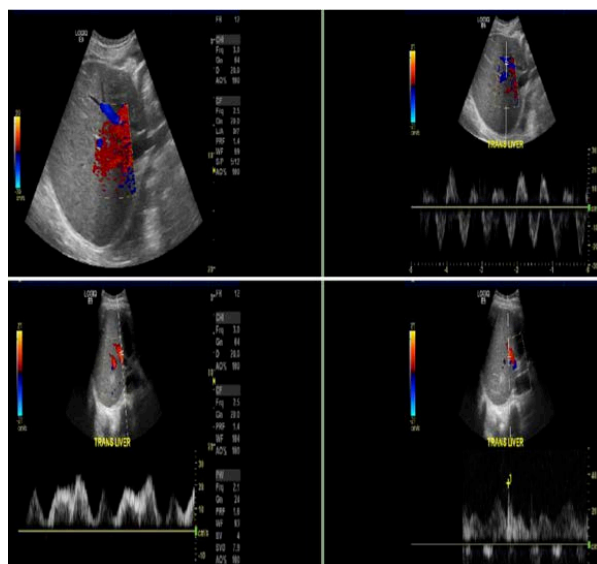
Ultrasonography liver: Mild diffuse coarse hepatic echotexture. 2.2 cm nonvascular echogenic focus posterior right hepatic lobe, potentially hemangioma likely reflecting roughly 2 cm partially low-density lesion with peripheral nodular enhancement posterior right hepatic lobe on CT limited in characterization with single-phase imaging but suggestive of hemangioma. Partially distended gallbladder with borderline gallbladder wall thickening. No sonographic findings to suggest acute cholecystitis.
